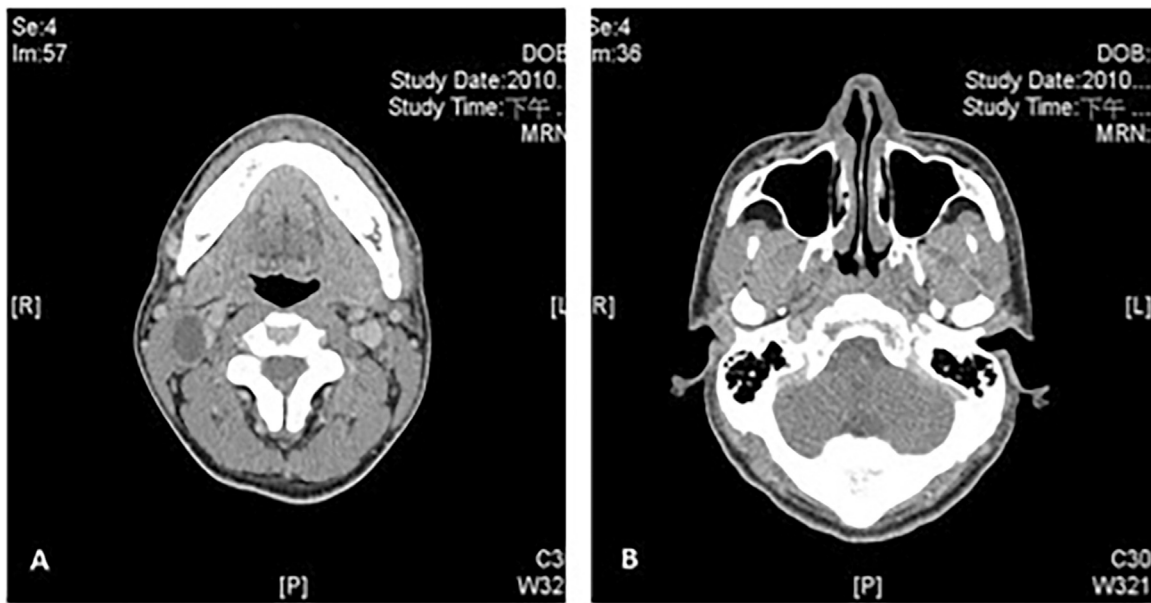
(A) Axial CT of head and neck region shows a well-circumscribed cystic swelling in the upper part of the left neck, anteromedial to sternocleidomastoid muscle. The cyst measures 1.8×2.5 cm. No other apparent pathologies or enlarged lymph nodes. (B) The nasopharynx shows normal lining appearance. Neither soft tissue masses nor ulcerations could be detected.
